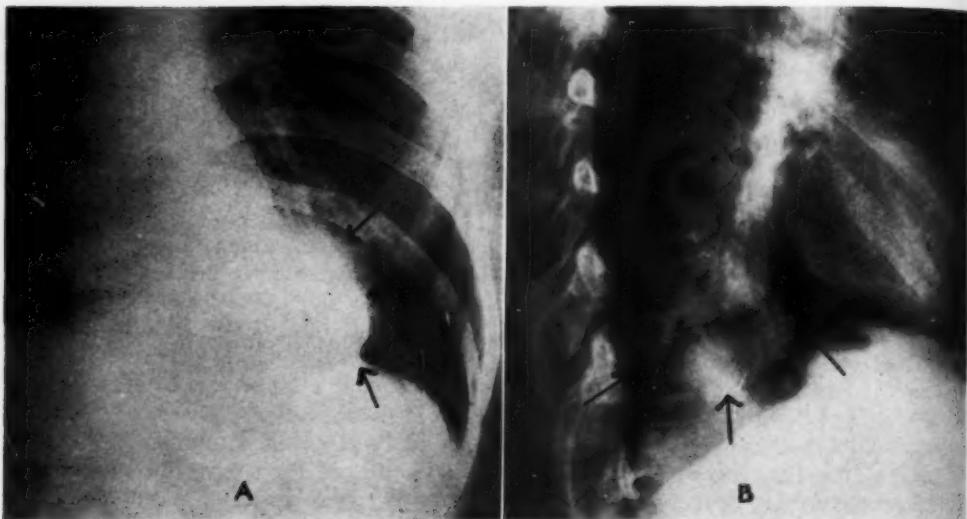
Case 1: Cyst of the lung without infection. A. Sharply rounded, well defined dense shadow just lateral to the apex of the heart. No gas is shown within it. Roentgenogram made Jan. 12, 1942. B. Lateral view, after institution of pneumothorax, showing mass within the lung, collapsing away from chest wall, but lying well behind the heart and distinct from it. Roentgenogram made Jan. 13, 1942.
